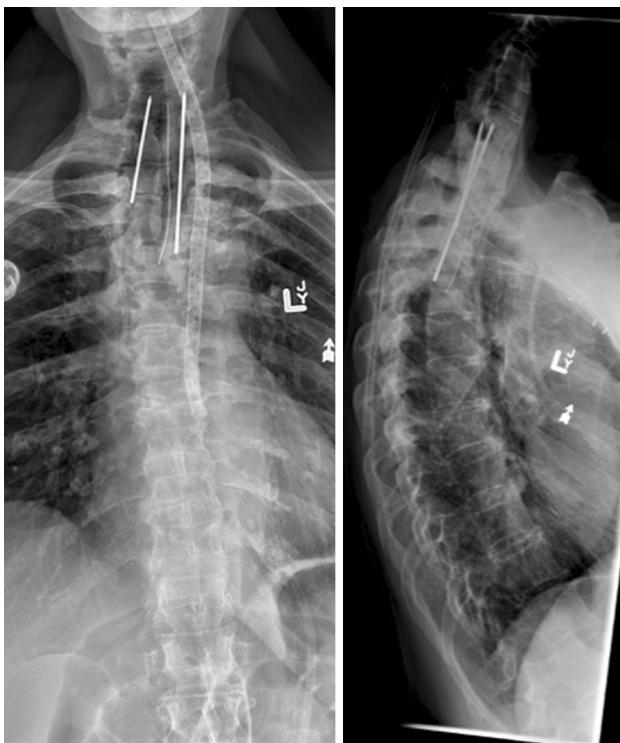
X-rays of the upper thoracic spine after removal of the posterior instrumentation
